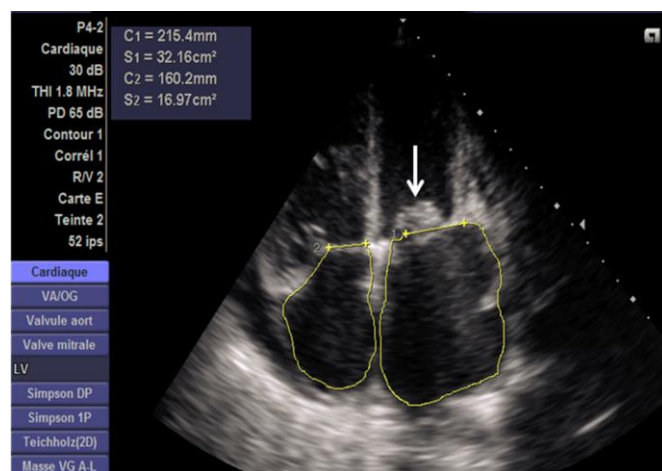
Apical 4-cavity view showing mitral valve remodelling with fusion and calcification and leaflet fusion, dilatation of the atria.
